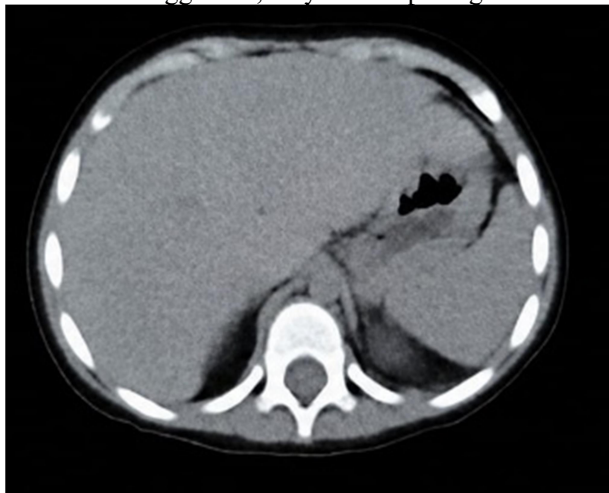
The following axial computed tomography images show a liver of normal shape and density, with no evidence of masses or intrahepatic bile duct dilation. The liver is enlarged, with the right lobe measuring 9.8 cm, consistent with hepatomegaly.
